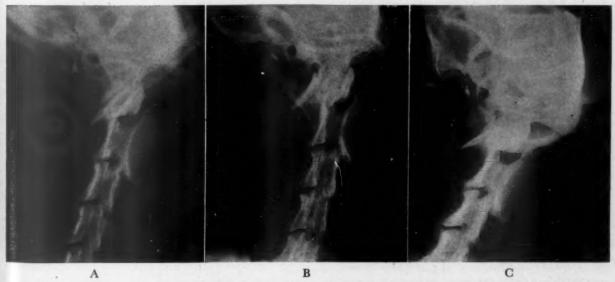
X-ray films showing radiopaque clot in carotid artery unaffected by intravenously administered fibrinolysin. A, before treatment. B, three hours after treatment. C, fourteen days after intravenous therapy.
